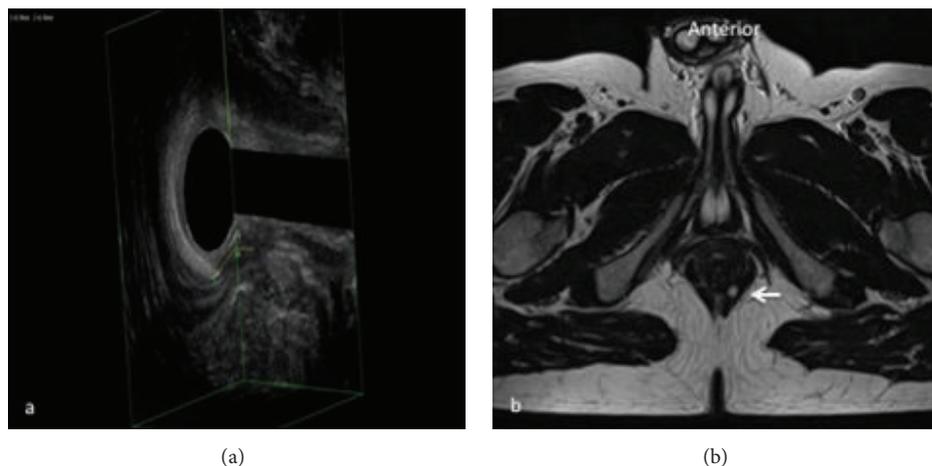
Transsphincteric fistula at 5 o'clock. Both 3D-EAUS (calibers) (a) and MRI (white arrow) (b) are accurate in the detection of transsphincteric fistulas. Thanks to 3D technique 3D-EAUS may show the entire extension of the fistula while on MRI it appears on two different planes.
